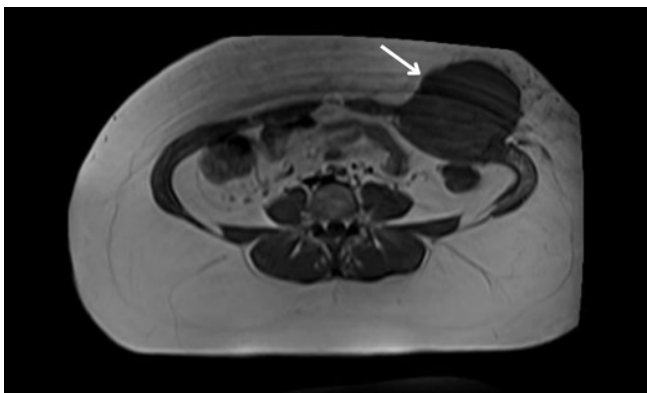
Follow-up magnetic resonance imaging of the mass (arrow).
